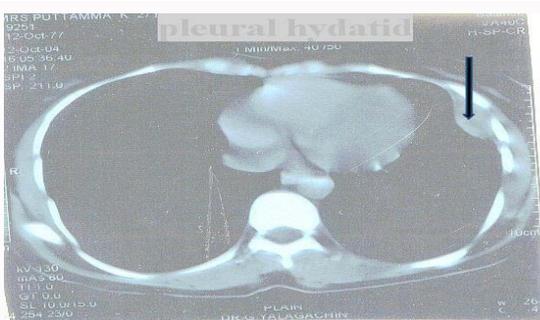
Plain CT showing extra pleural Hydatid Cyst.
